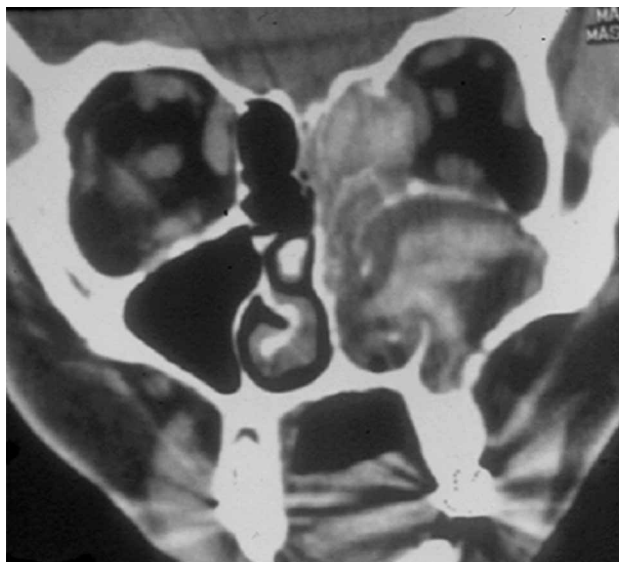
Computed tomographic scan. Coronal view showing a pseudotumoral appearance of the left maxillary sinus cavity.
